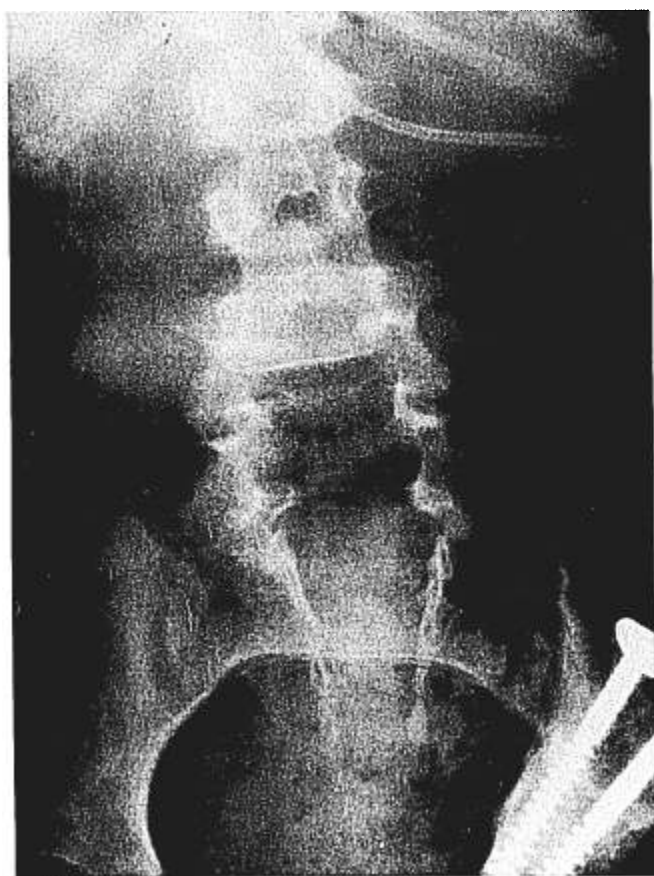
X-ray of case 4 showing L4-L5 myelodysplasia.
